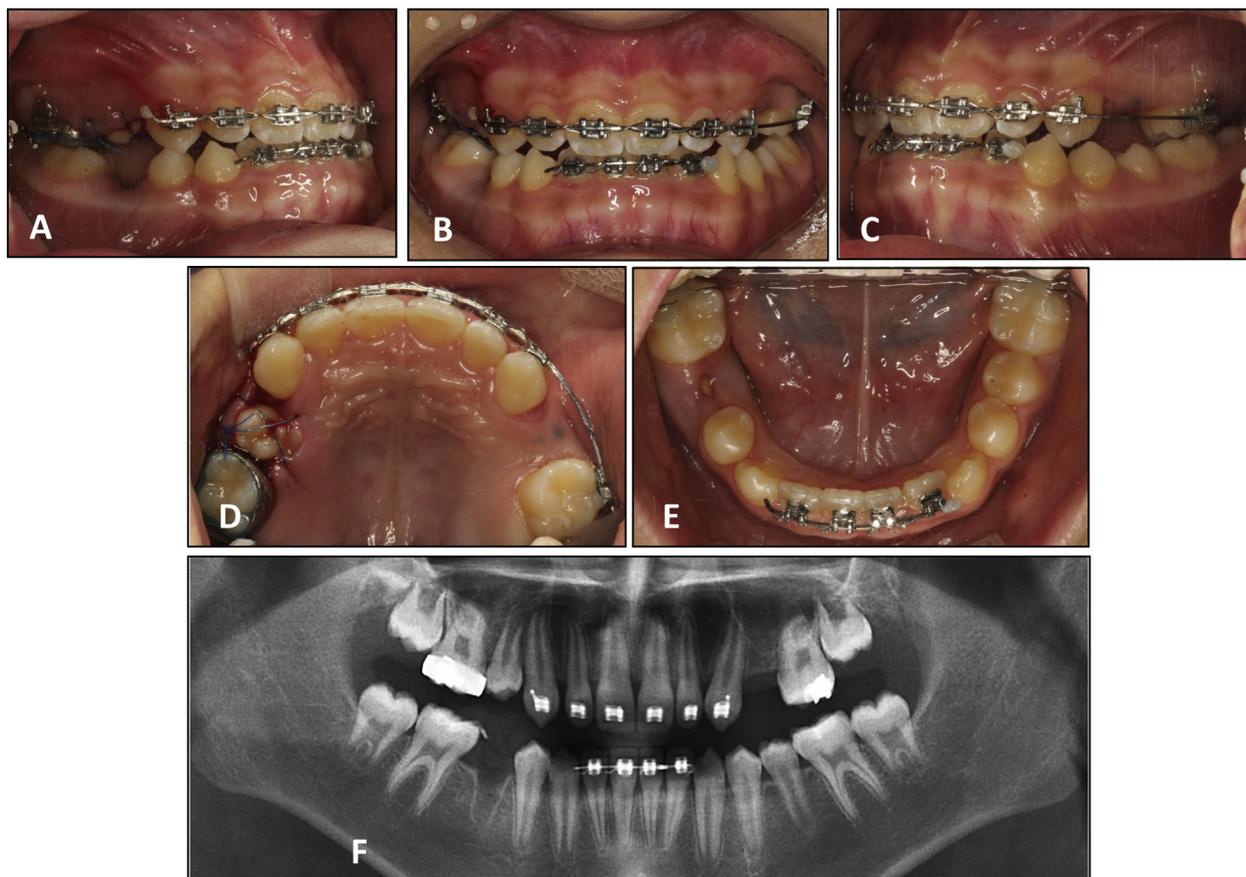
A-E, intraoral view, and F, panoramic radiography after transplantation on right side (11 years 11 months of age).
